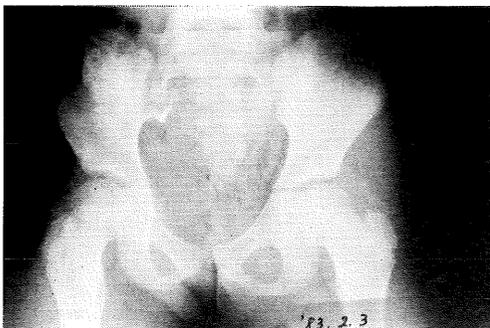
X-Ray of the pelvis taken on Feb. 3, 1983.
